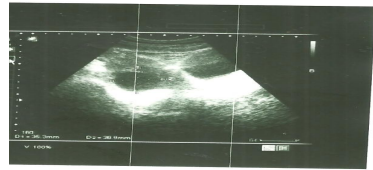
Figure six:43 old Ultrasound show complicated ovarian cyst
